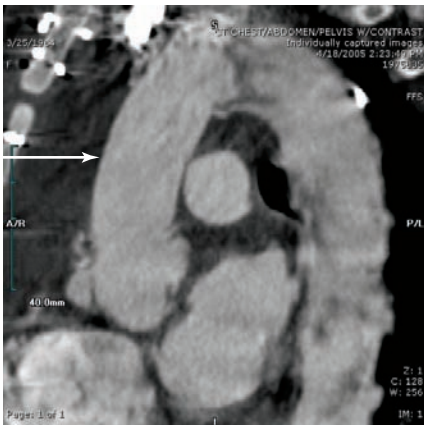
Magnetic resonance imaging of the thorax showing a repaired proximal aortic dissection with a graft. www.medreviews.com
